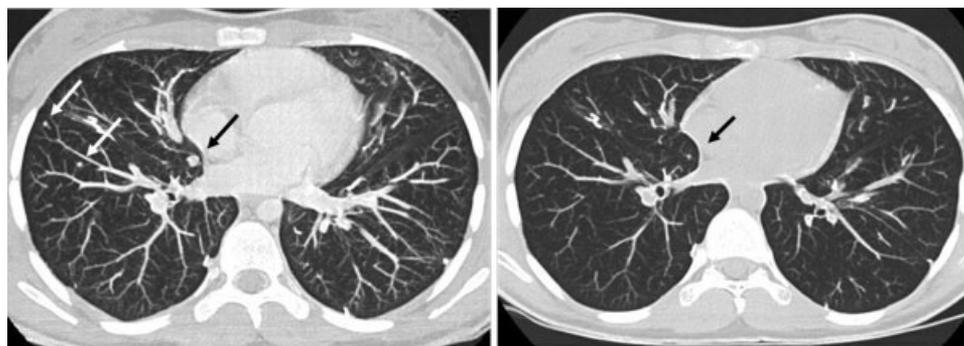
Chest CT scan (unenhanced 1.25 mm slice thickness with 8 mm maximum intensity projection reconstruction) of patient no. 1 before and after 18 months of sunitinib therapy, demonstrating complete regression of two right lower lobe metastases and very good partial response (1.5 mm vs. 6.5 mm) of one right middle lobe metastasis.
